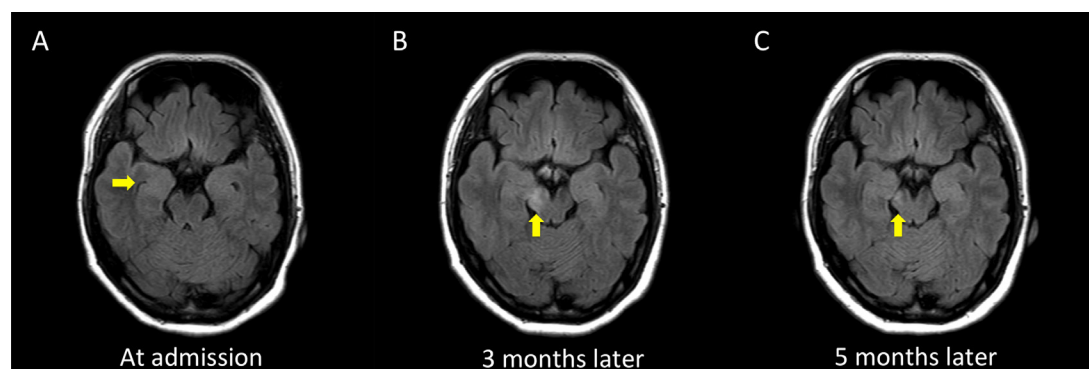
(A) At admission, high signal change and swelling in the limbic system are detected on fluid-attenuated inversion recovery MRI (arrow). There is no change on diffusion-weighted MRI. (B) Three months later, the ventral side of the right middle brain showed high signal change and swelling on fluid-attenuated inversion recovery MRI (arrow). The patient did not exhibit any symptoms. (C) Five months later, the change at the right middle brain disappeared without atrophy.
